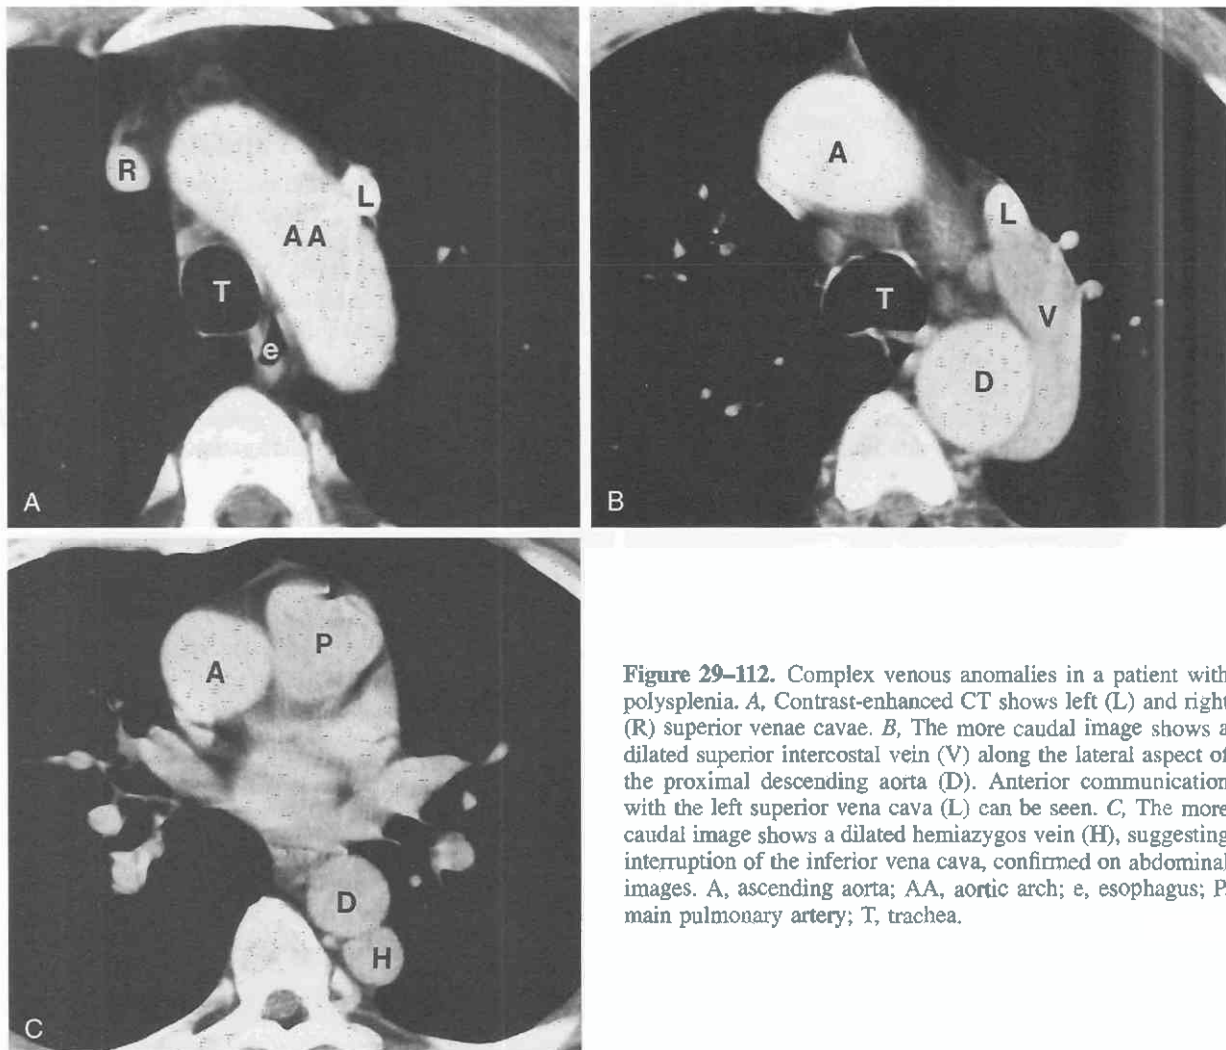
Complex venous anomalies in a patient with polysplenia. *A*, Contrast-enhanced CT shows left (L) and right (R) superior venae cavae. *B*, The more caudal image shows a dilated superior intercostal vein (V) along the lateral aspect of the proximal descending aorta (D). Anterior communication with the left superior vena cava (L) can be seen. *C*, The more caudal image shows a dilated hemiazygos vein (H), suggesting interruption of the inferior vena cava, confirmed on abdominal images. A, ascending aorta; AA, aortic arch; e, esophagus; P, main pulmonary artery; T, trachea.
